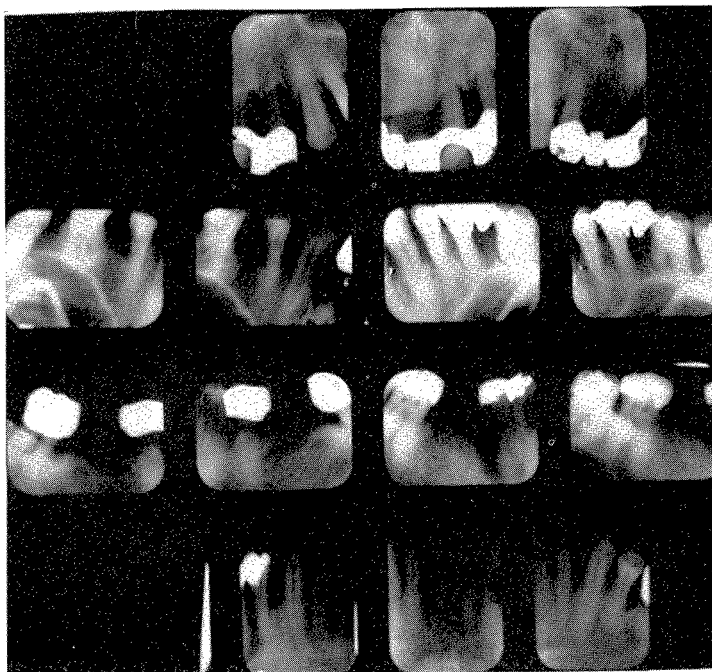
Roentgenograms taken in February, 1936, just prior to the rehabilitation of the mouth.
